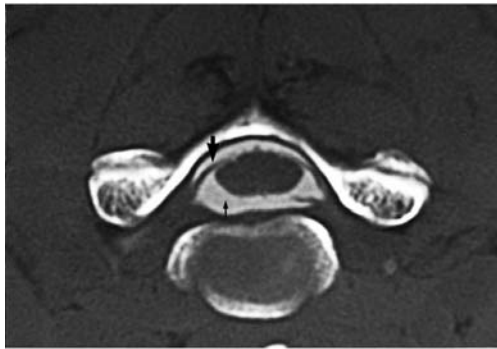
CT myelogram of a complete C5–T1 brachial plexus avulsion lesion. Negative images of the roots are seen on the intact side, as well as cranial to the multiple meningeoceles on the injured side.
